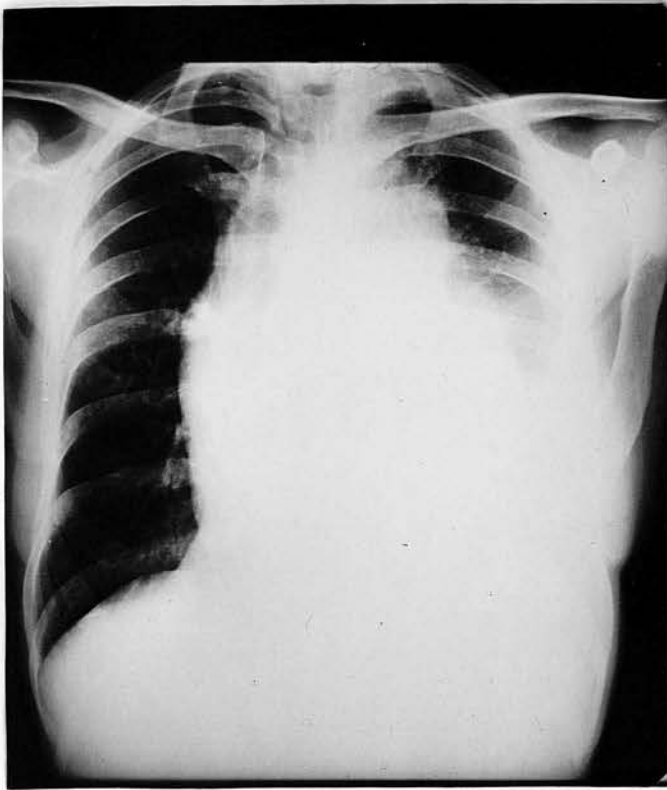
Case No. 7. Radiograph of chest (a) before treatment, and (b) after treatment with 6-MP, showing diminution in size of pleural effusion and mediastinal lymph nodes.
